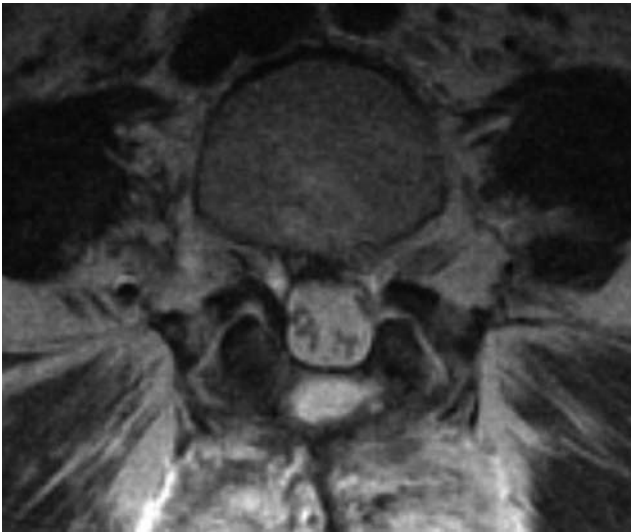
Case 2. Postoperative axial MR image showing successful fenestration of an arachnoid cyst with good decompression of the cauda equina.
